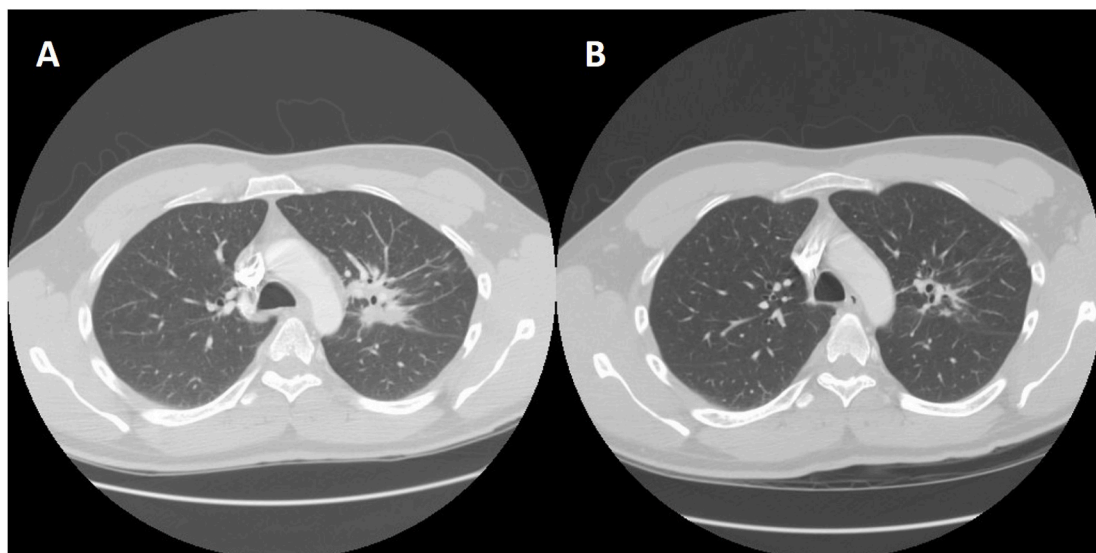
(A) Chest CT with contrast, showing nodular infiltrates on + Day 62. (B) Chest CT with contrast, showing nodular opacities much improved on + Day 194.
